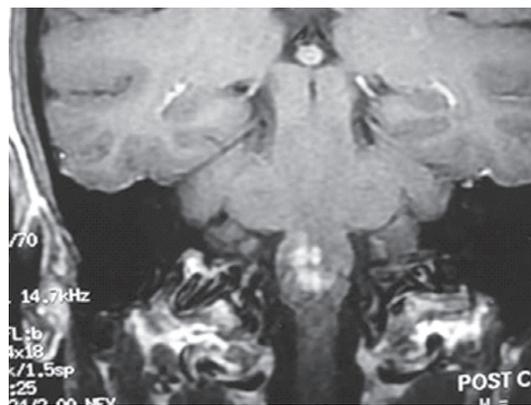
Brain stem abscess. Magnetic resonance imaging with gadolinium shows an enhancing lesion in the brain stem caused by *Listeria* species infection.
